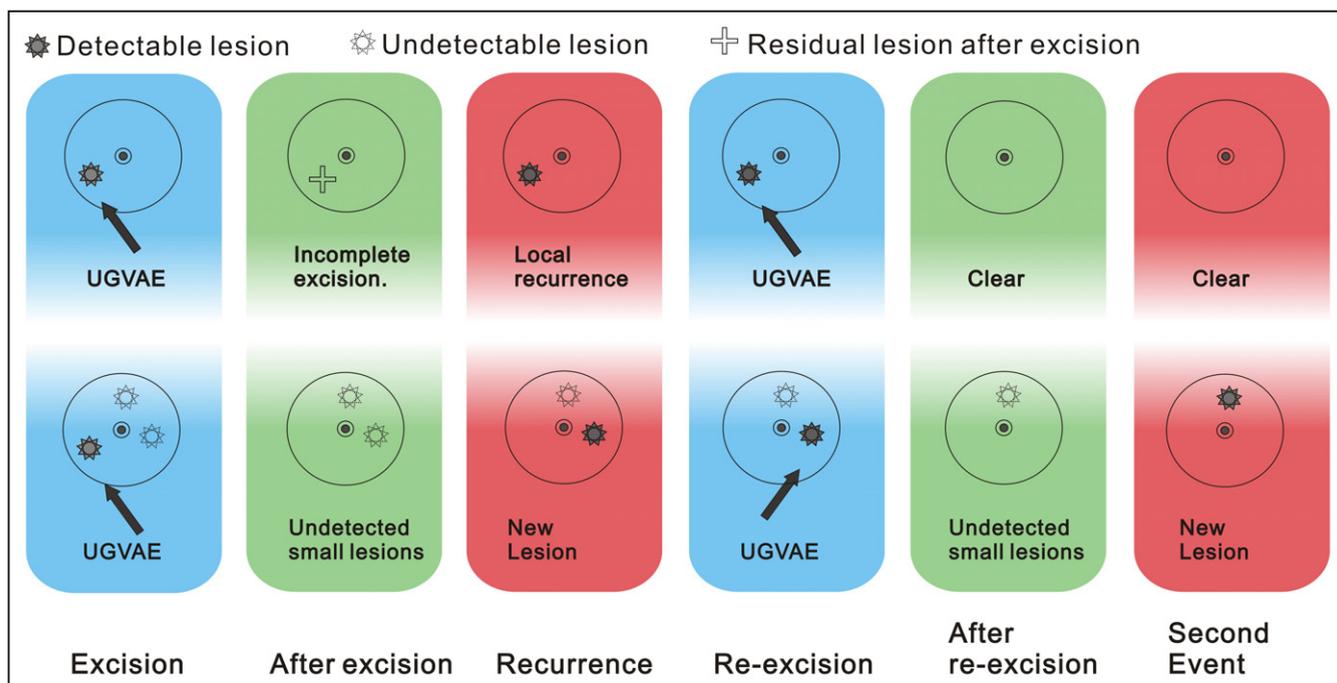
The hypothesis of the mechanism underlying the different patterns of recurrence. An incomplete excision may lead to local recurrence. Re-excision in these patients is worthwhile to achieve lesion clearance. For patients with new lesions, small lesions that cannot be detected by ultrasound during the initial treatment or the sites that were prone to have abnormal changes may be the cause. Re-excisions might not be worthwhile because second new lesion events may still occur.
